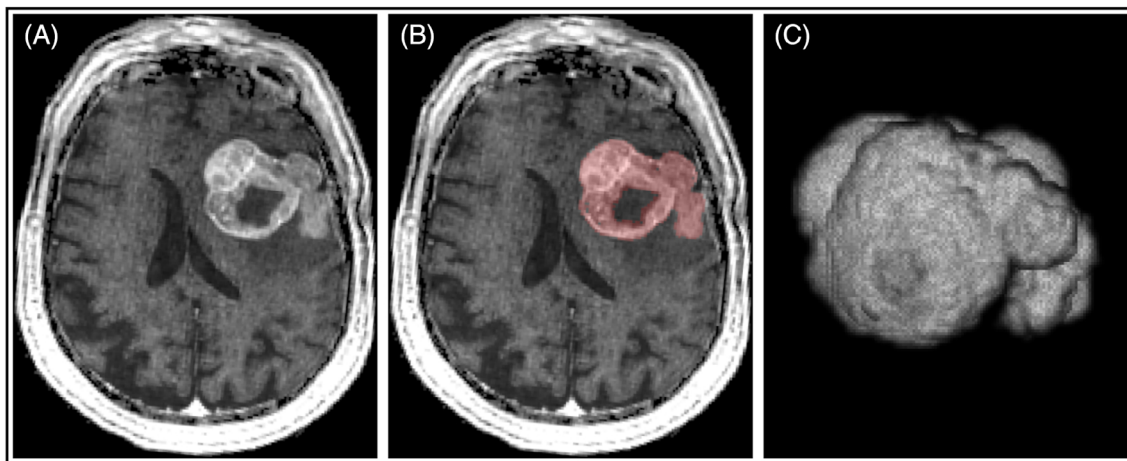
Example of lesion segmentation on synthetic images. The pathological enhancing tissue was detected (A) and segmented on post-contrast T1-weighted images (light red in B). Panel C shows the volume rendering of the segmented lesion.
